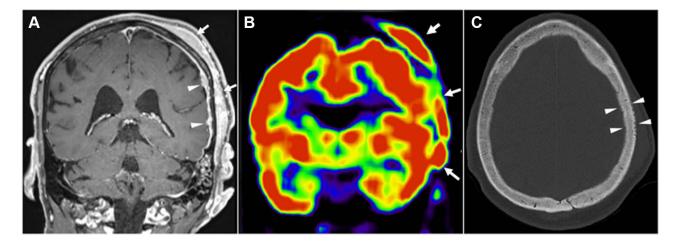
Figure I Initial FDG PET-MRI Images. (A) Coronal contrast enhanced TI weighted MRI shows infiltrating subgaleal mass (arrows) with abnormal enhancement of the underlying calvarial marrow and nodular thickening of the dura (arrowheads). (B) The infiltrating mass is hypermetabolic on FDG-PET (arrows). (C) High-resolution CT of the skull reveals permeative erosions and slightly increased density of the involved parietal bone.
